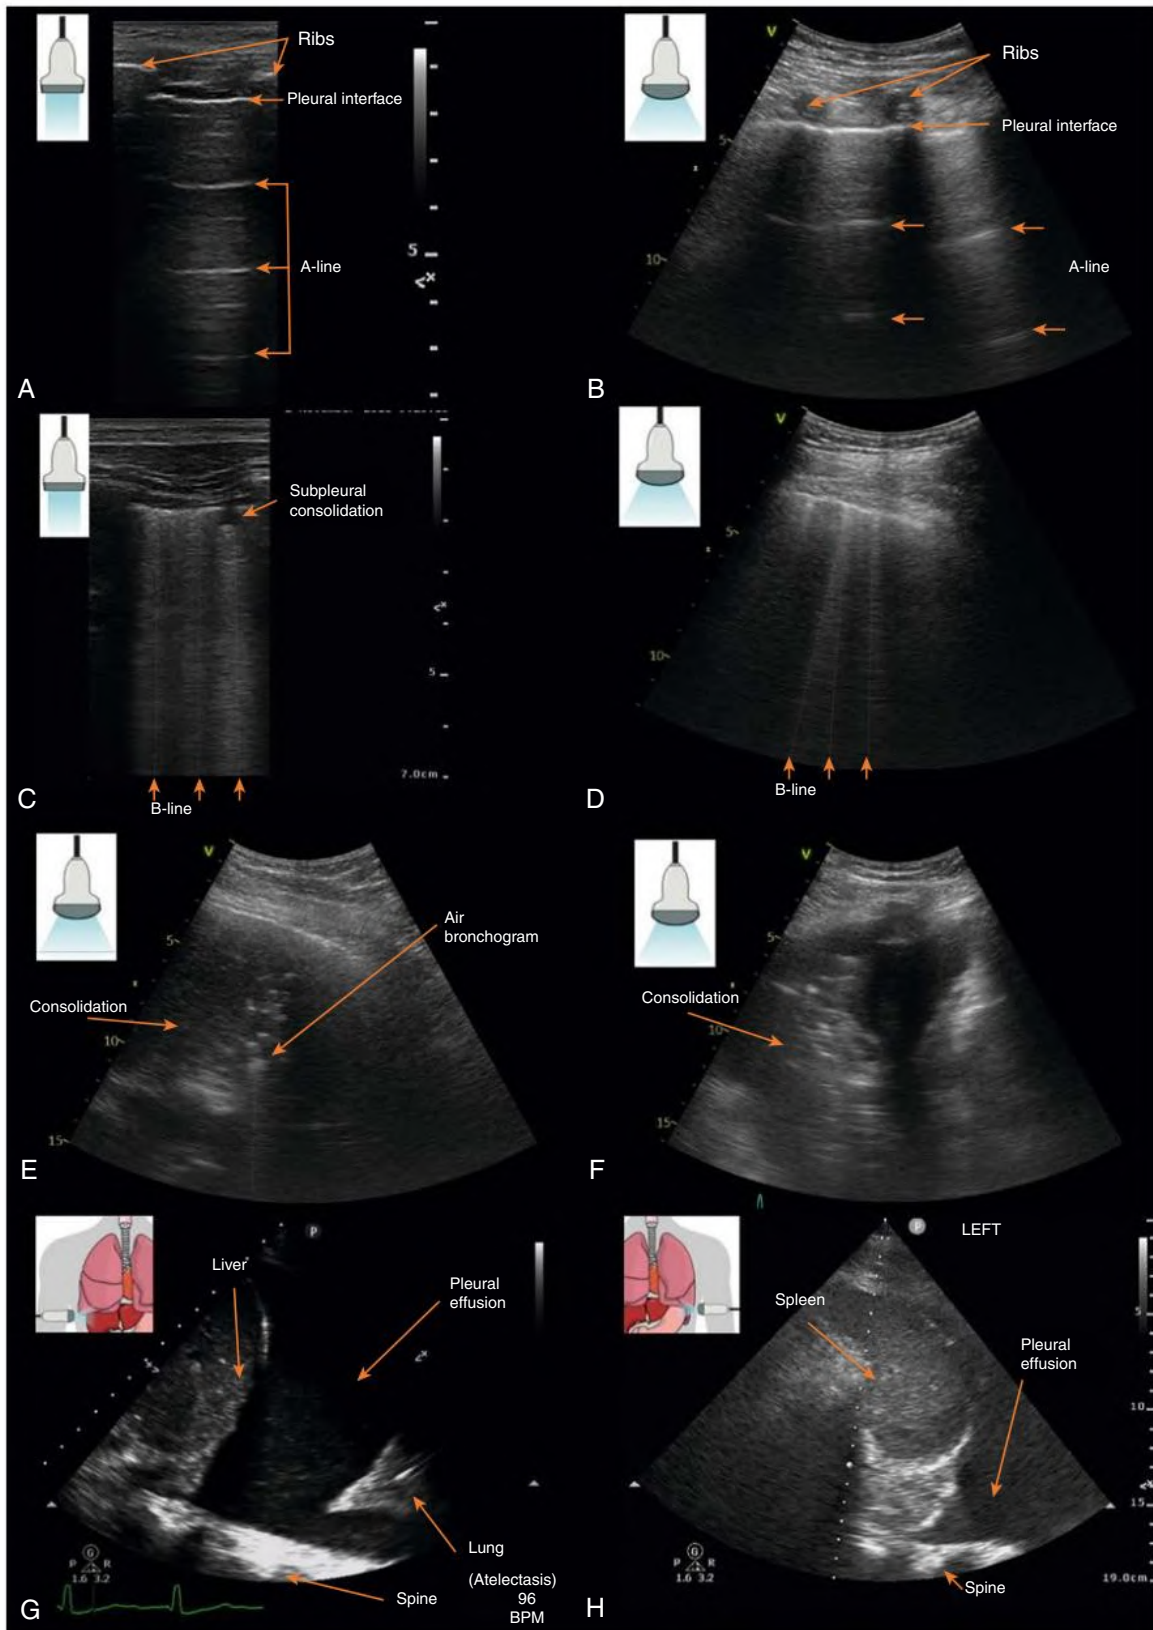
Examples of Lung and Pleural Ultrasound. Normal ultrasound (A-line pattern) using a linear transducer (A) and a curvilinear transducer (B). B-lines shown using a linear transducer (C) and a curvilinear transducer (D). Note that B-lines move with respiration (see Video 5.4). Examples of lung consolidation (also referred to as the C-pattern) showing a heterogeneous tissue-like appearance (E–F). Pleural effusion of the right lower thorax region (G) and to the left lower thorax region (H).
